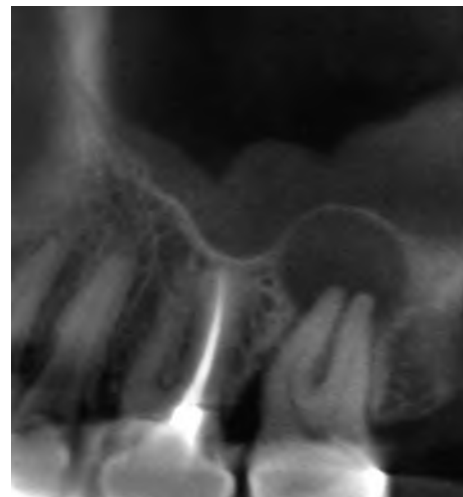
Periapical osteoperiostitis with mucositis. Sagittal CBCT image of a necrotic left maxillary second molar displaying osteoperiostitis ("halo" lesion) with associated mucosal edema.
